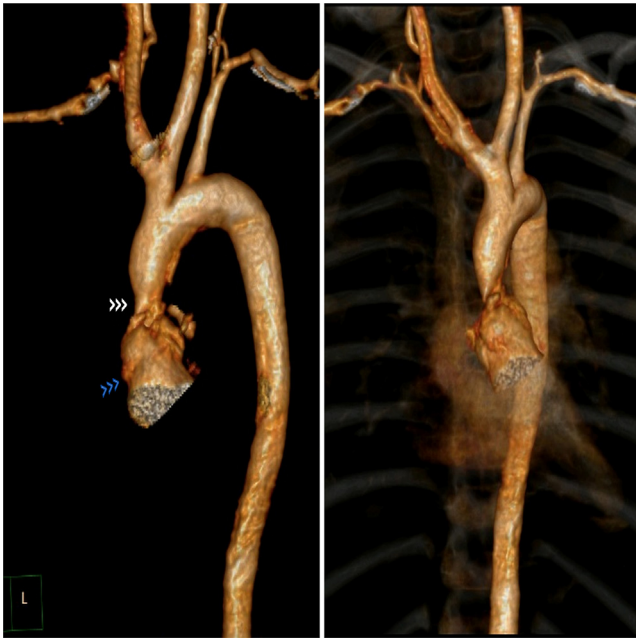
CT angiogram with 3D reconstruction showing the supravalvular aortic stenosis (white arrow heads) and aortic annulus (blue arrow heads). Left aortic arch with the first arch as a common trunk for innominate and left carotid artery (BAA) following which the arising of the left subclavian artery can also be appreciated.
